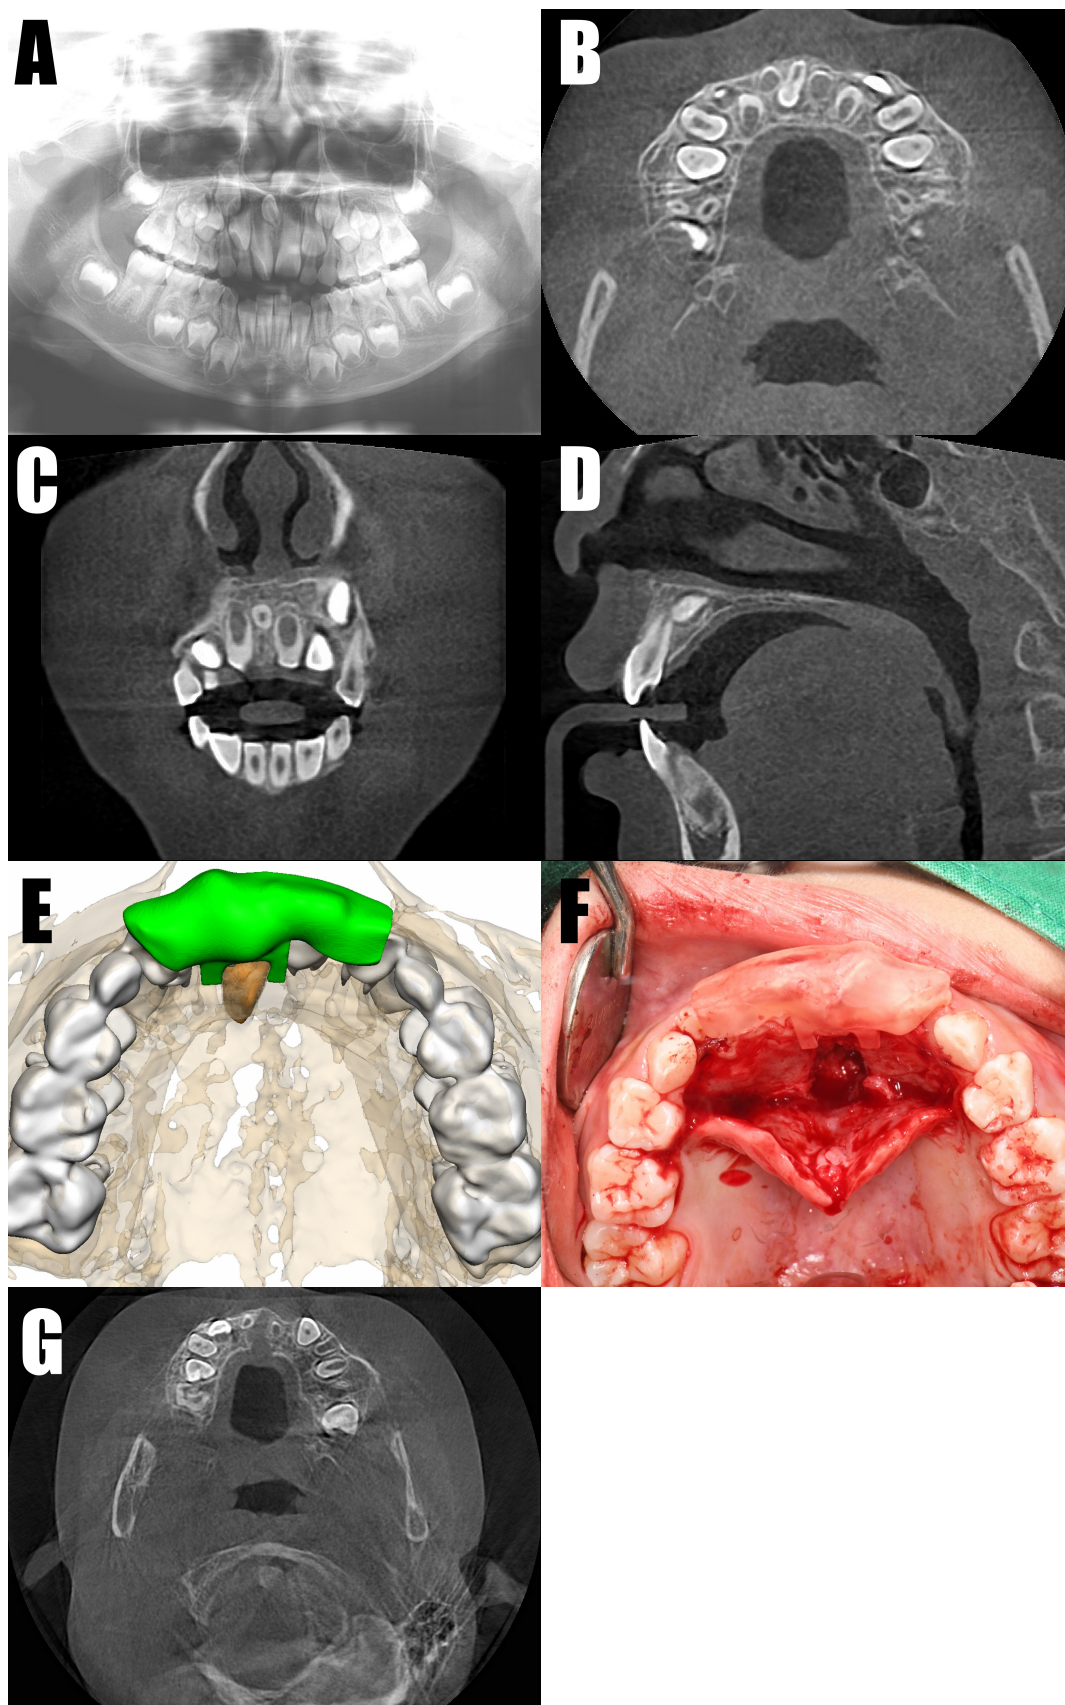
Preoperative panoramic, CT, appliance, clinical photograph, postoperative CT for case 1. (A) Initial panoramic view. (B) Initial axial view on CT. (C) Initial coronal view on CT. (D) Initial sagittal view on CT. (E) Surgical guide model. (F) Intraoperative intraoral photograph. (G) One-week postoperative CT view. CT: computed tomography.
